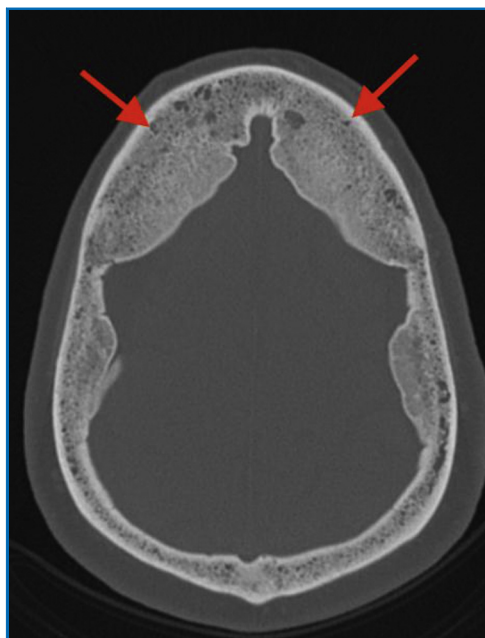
Axial computed tomographic bone window image depicting advanced calvarial hyperostosis, worst at the frontal regions (arrows) but also involving the parietal calvaria.
